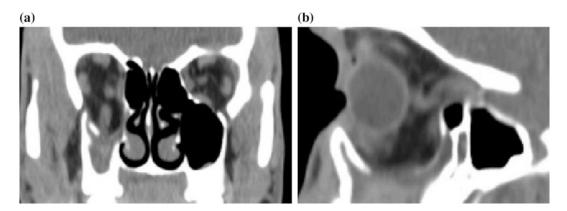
Coronal (a) and sagittal (b) orbital CT scan showing a large displaced right orbital floor fracture with prolapse of orbital soft tissues into the maxillary sinus
